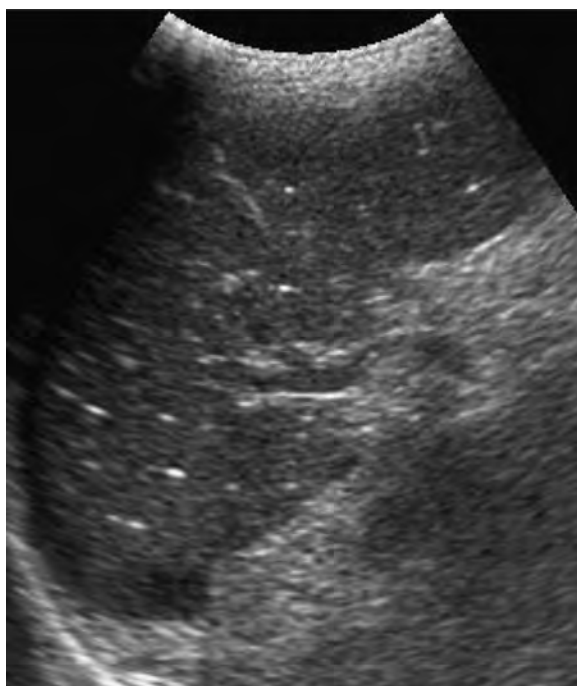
Pneumocystis jiroveci* pneumonia. Longitudinal ultrasound image demonstrates multiple, punctate calcifications after successful treatment.
